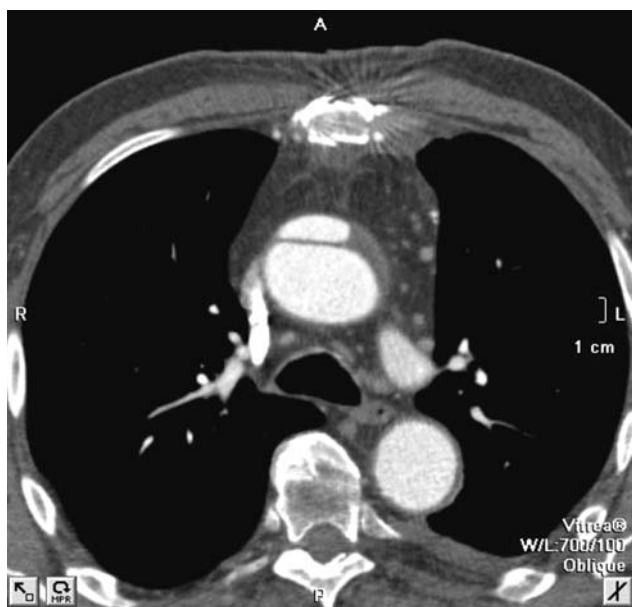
Preoperative CT scan demonstrating type A dissection
